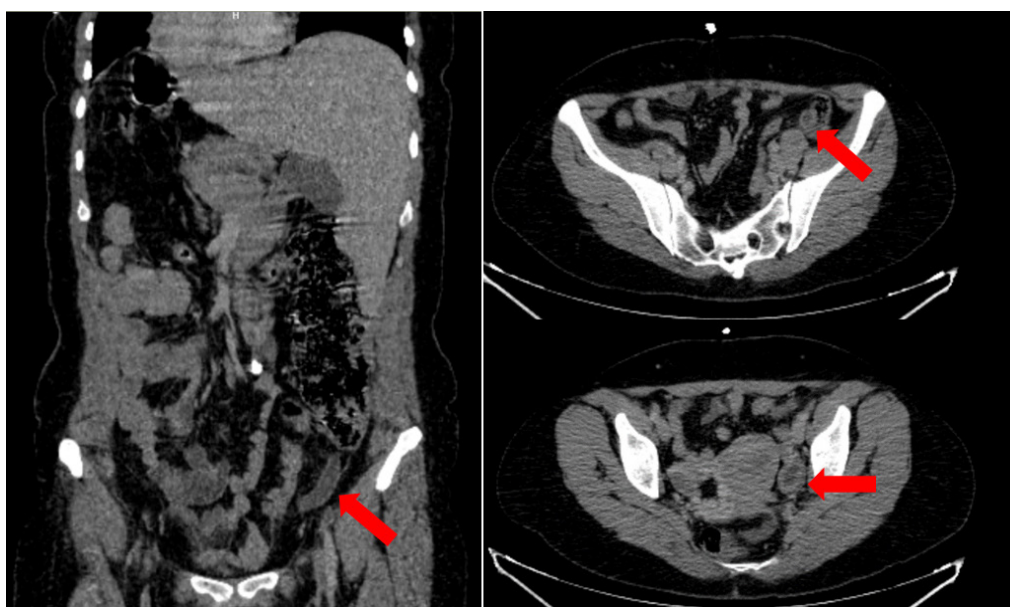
Appearance of 13.5 mm acute appendicitis in the coronal plane (left) and axial plane (top right) and left ovarian cyst (bottom right) with accompanying situs inversus in abdominal computed tomography examination (red arrow)
